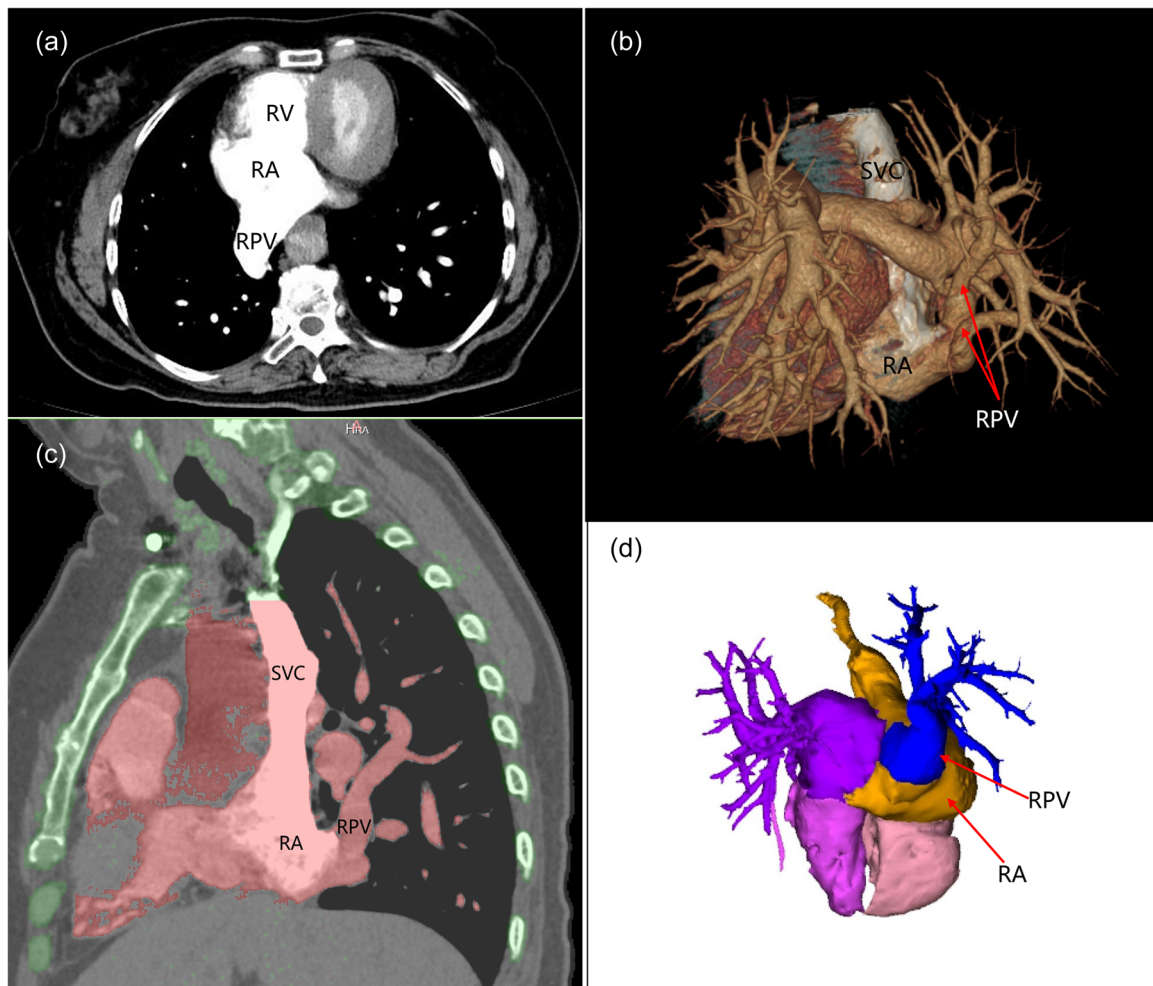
(a) CTA imaging shows the right pulmonary vein is dilated, with abnormal reflux into the right atrium. (b–d) Clear visualization of abnormal reflux of the right pulmonary vein into the right atrium is evident in the 3D reconstructed images from CTA, multiplanar reformation reconstructed images from CTA, and vascular reconstruction images using Mimics Research 20.0 software. 3D, three-dimensional; CTA, computed tomography angiography; RA, right atrium; RPV, right pulmonary vein; RV, right ventricle; SVC, superior vena cava.
